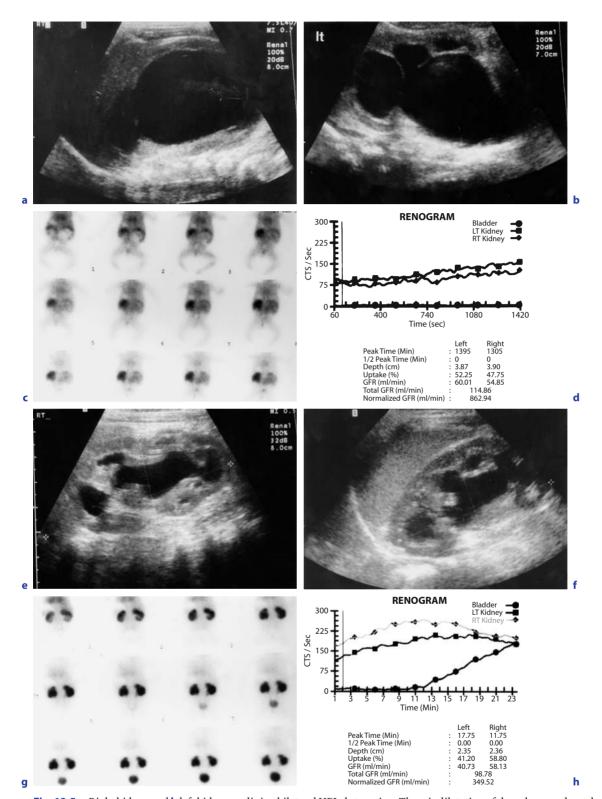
a Right kidney and b left kidney outlining bilateral UPJ obstruction. There is dilatation of the calyces and renal pelvis on both sides. c,d Preoperative Tc 99m DTPA scintigraphy showing poor uptake of the radiopharmaceutical bilaterally with no significant detectable excretion. e Right kidney and (f) left kidney after pyeloplasty. There is a significant reduction in the degree of hydronephrosis and an increase in cortical thickness. g,h Postoperative Tc 99m MAG 3 renogram 1 year after operation. There is improved function in both kidneys, more on the right than on the left side, with an improvement in excretion
